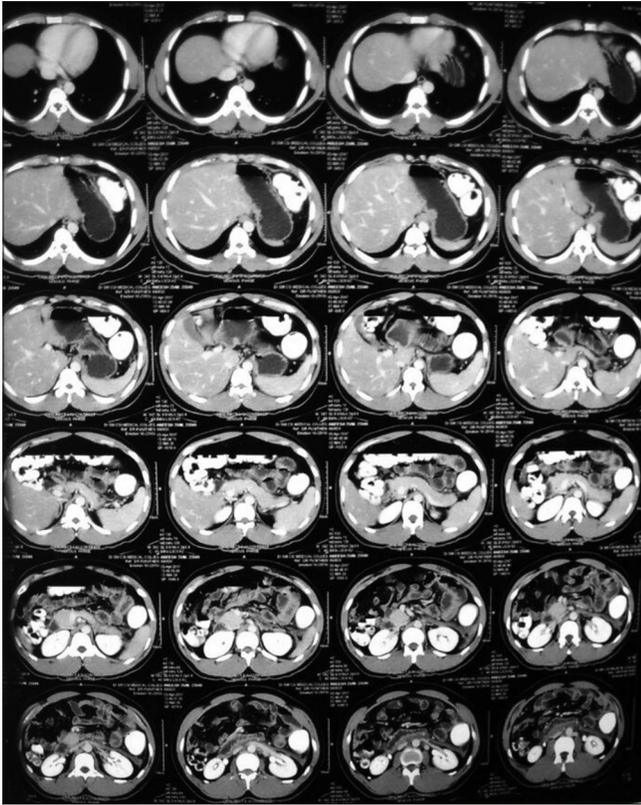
Computed tomography abdomen-Axial view
